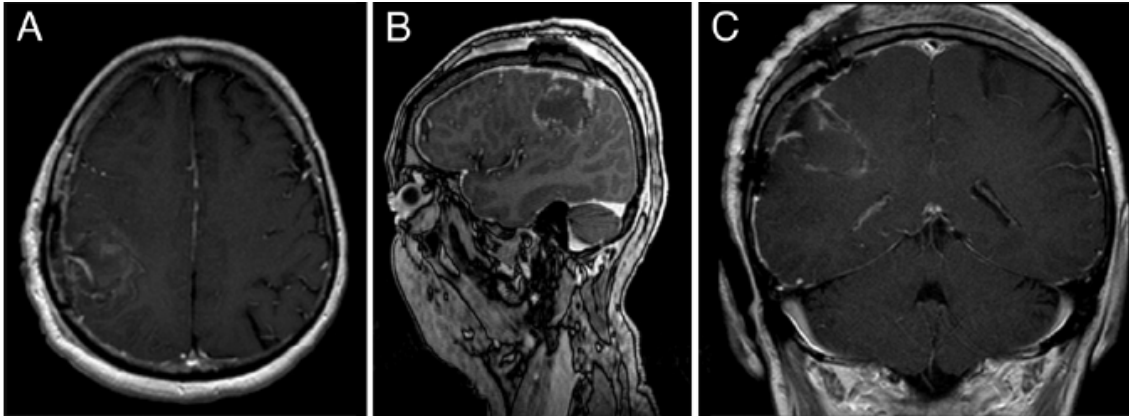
Postoperative axial (A), sagittal (B), and coronal (C) contrast-enhanced MR images obtained 24 hours after surgery, showing a 93% reduction in tumor volume. Resection had to be stopped in an area with fluorescent tumor tissue still visible near the pyramidal tracts because of positive subcortical stimulation. Postoperatively, the patient showed no new neurological deficits.
